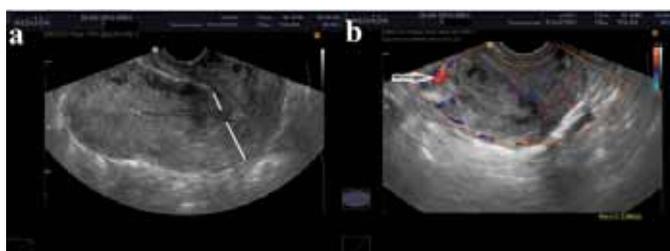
Ultrasound after UAE and methotrexate administration before repeated D&C in the Municipal Hospital: (a) Asymmetry of the walls thickened at the isthmus level (lines), (b) Persistent peripheral blood flow (arrow).
